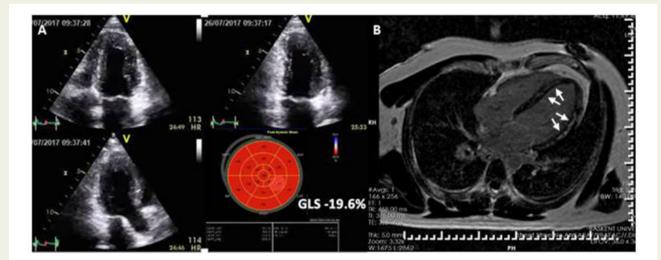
Lupus myocarditis in a 32-year-old woman with chest pain, arrhythmias, elevated C-reactive protein, troponins, and normal coronaries. (A) 2D echocardiography shows normal systolic function, but global longitudinal strain (GLS) is at the lower limit of normal. (B) Cardiac magnetic resonance shows extensive mid-wall late gadolinium hyperenhancement (arrows).
